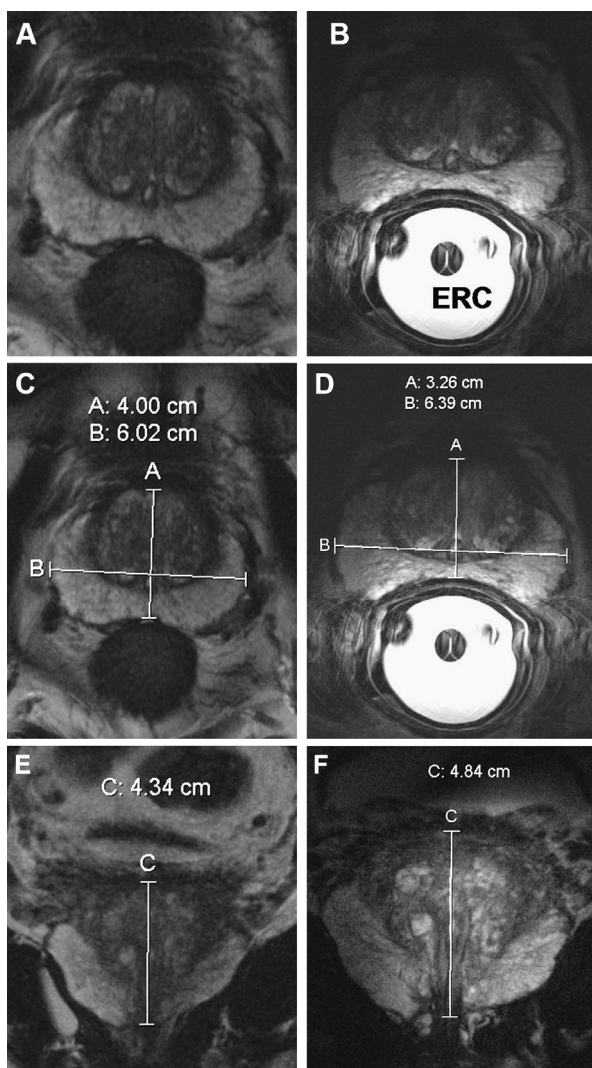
Example of MR images obtained with (A,C,E) external surface coils and (B,D,F) endorectal coil (ERC) filled with demineralized water. (C,D) Maximal prostate diameter change after introduction and inflation of ERC in anteroposterior direction decreased by 18.5% and right-to-left diameter increased by 6.1%. (E,F) Maximal craniocaudal diameter increased by 11.5%.
